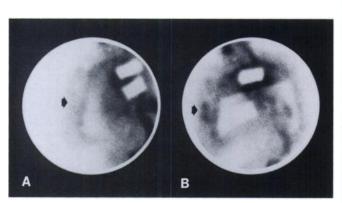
Anterior right-upper extremity scintigram after RBC labeling with ^{99m}Tc. (A) Five minutes postinjection, normal bloodpool activity is identified. At approximately 1 hr postinjection (B) a focus of accumulating activity was noted in the mid-portion of the right-upper arm (arrow) consistent with hemorrhage. Lead shields are placed over the chest.
